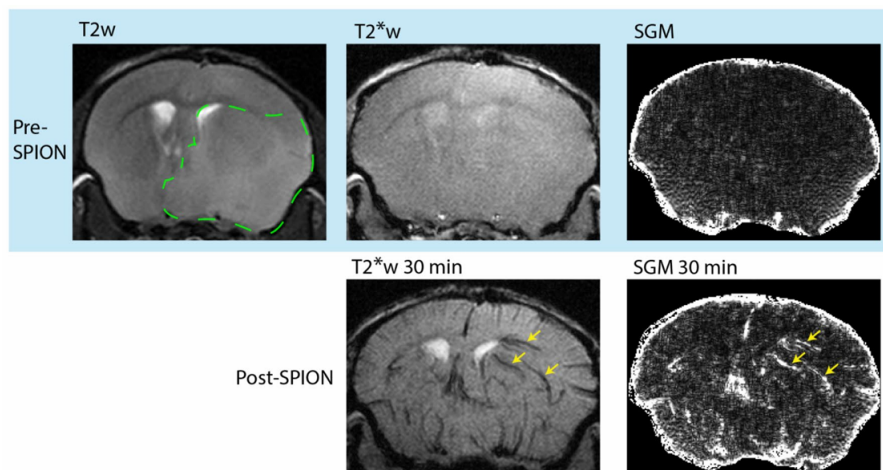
A - MRI imaging before and post-SPION injection. Patient with glioblastoma, abnormal blood vessels are visible in the right hemisphere post-SPION (yellow arrows) [7]
